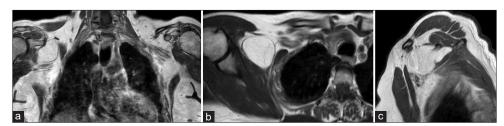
Preoperative magnetic resonance imaging showing a 6-cm non-enhancing lobulated mass in the right infraclavicular/axillary region. On coronal (a), axial (b), and sagittal (c) T1-weighted sequences, the mass is hyperintense; it has low signal on fat-suppressed T2-weighted images.
